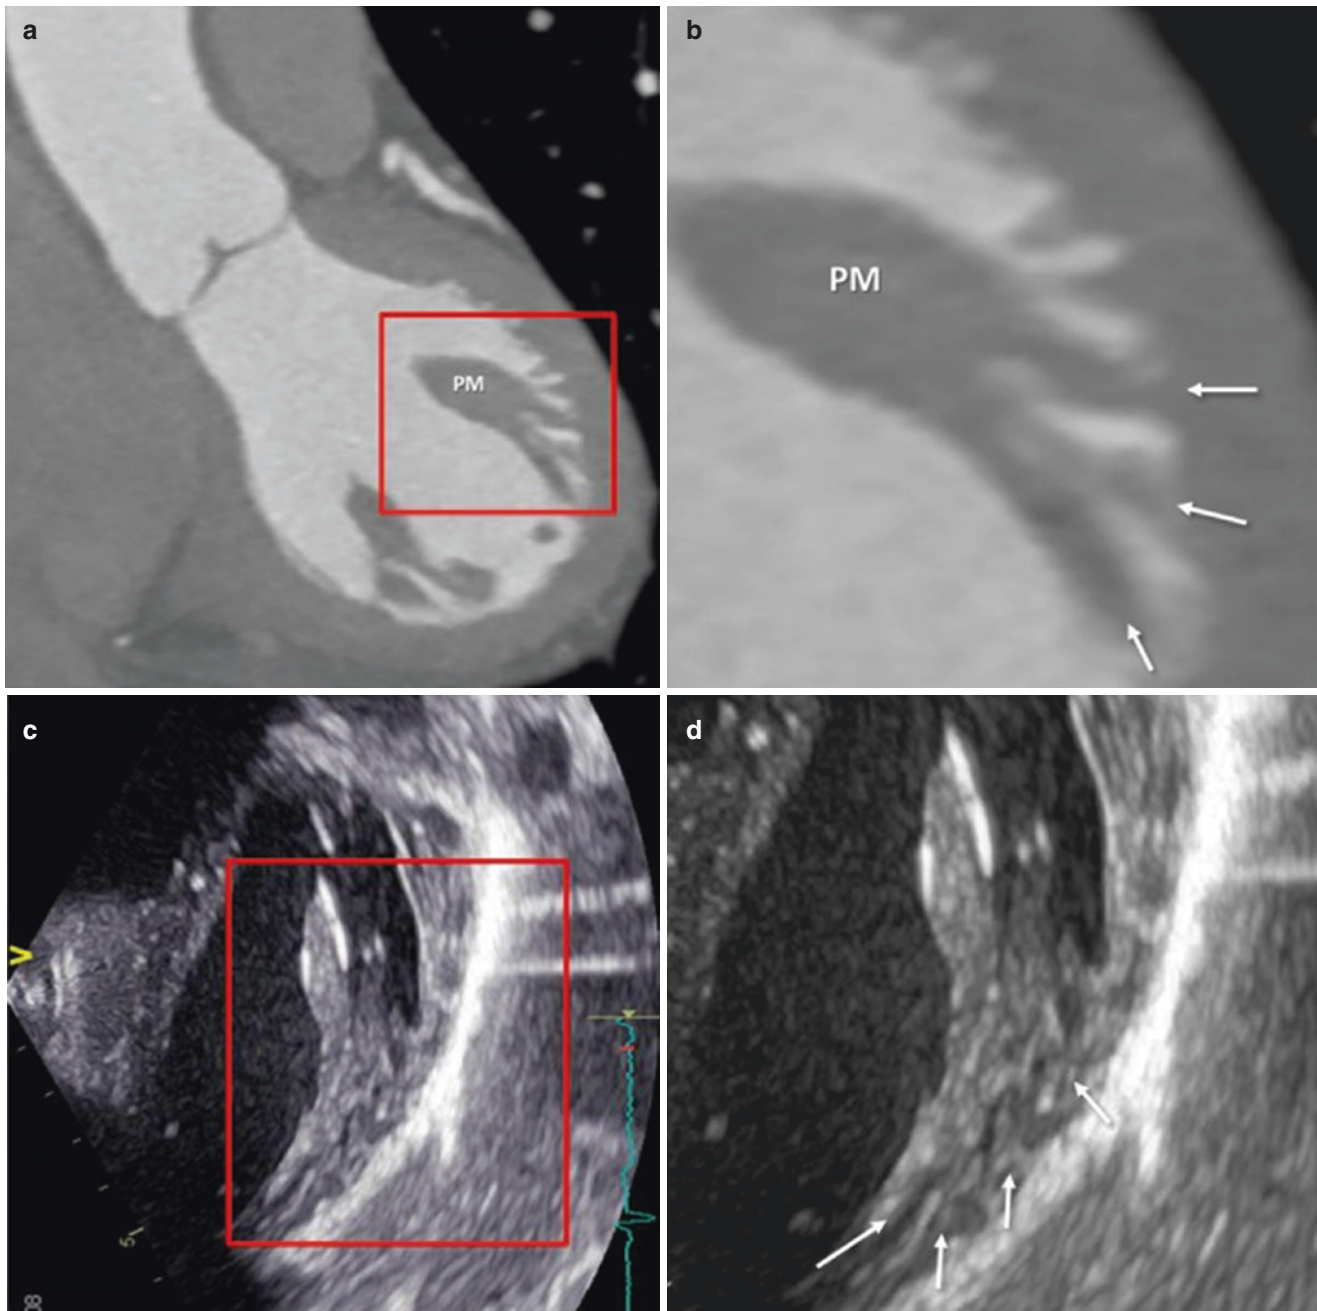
The base of a papillary muscle (PM), seen on a CT scan (a) and 2D TTE (c). In the magnified images (b and d), it can be seen that the PM arises from a network of trabeculations (*arrows*), not as a single pillar from the compact myocardium
